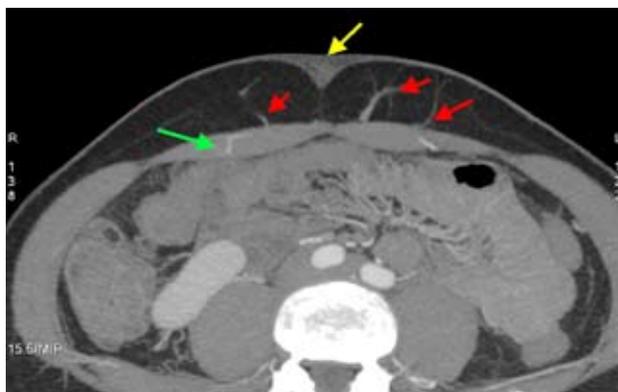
Angio-CT image. The image shows the perforators (red arrows), rectus abdominis (green arrow) and navel (yellow arrow)
